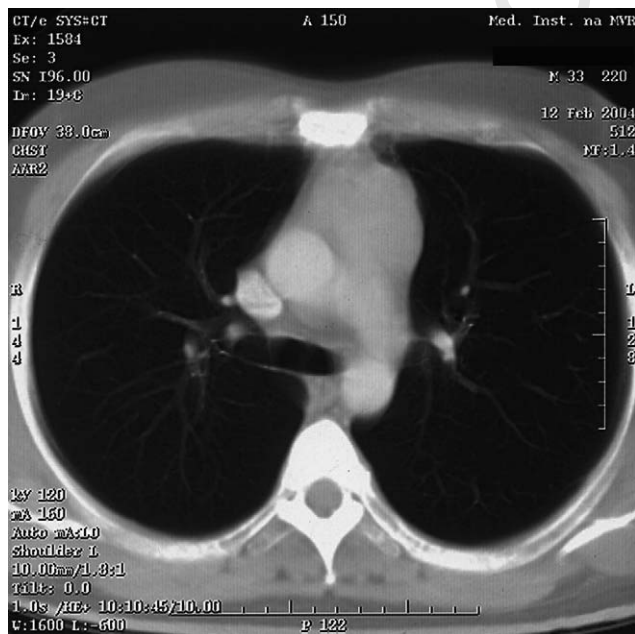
Contrast enhanced CT of thorax revealing a retrosternal mass in the anterior mediastinum.
